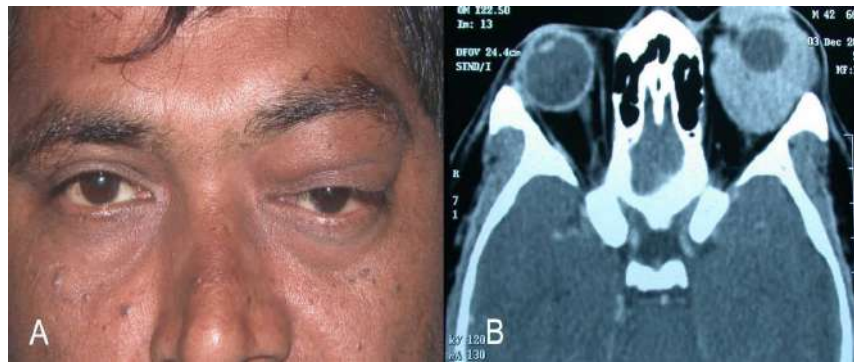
A 40-year-old male presented with mild slowly increasing proptosis of the left eye for 1 year (A). CT scan shows an isodense mass molding around the eye (B) suggestive of orbital lymphoma, which was confirmed on incisional biopsy.
